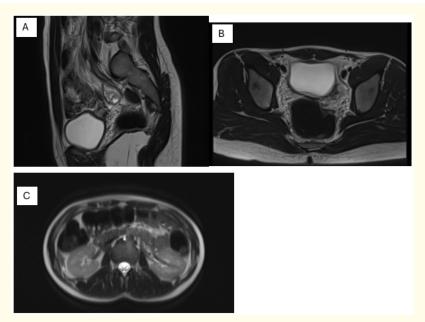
Figure A-C: A: Sagittal T2-weighted MRI showing complete uterine and upper vaginal agenesis with a short distal vaginal remnant posterior to the bladder. B: Axial T2-weighted pelvic MRI demonstrating bilateral normal ovaries with no identifiable uterine structure. C: Axial T2-weighted abdominal MRI confirming normal kidneys in position and morphology, ruling out renal malformations.
